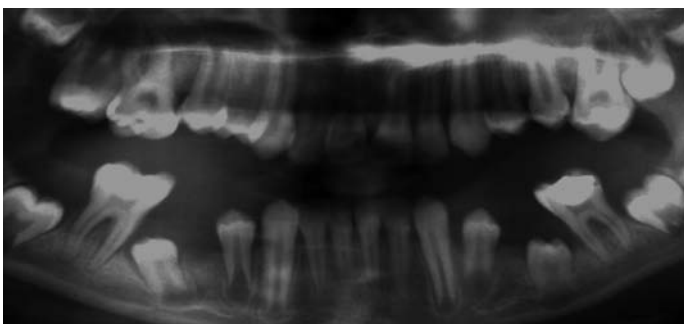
Panoramic radiograph of the male patient. Note the furcation lesions and alveolar bone loss in the mandibular first molars.
